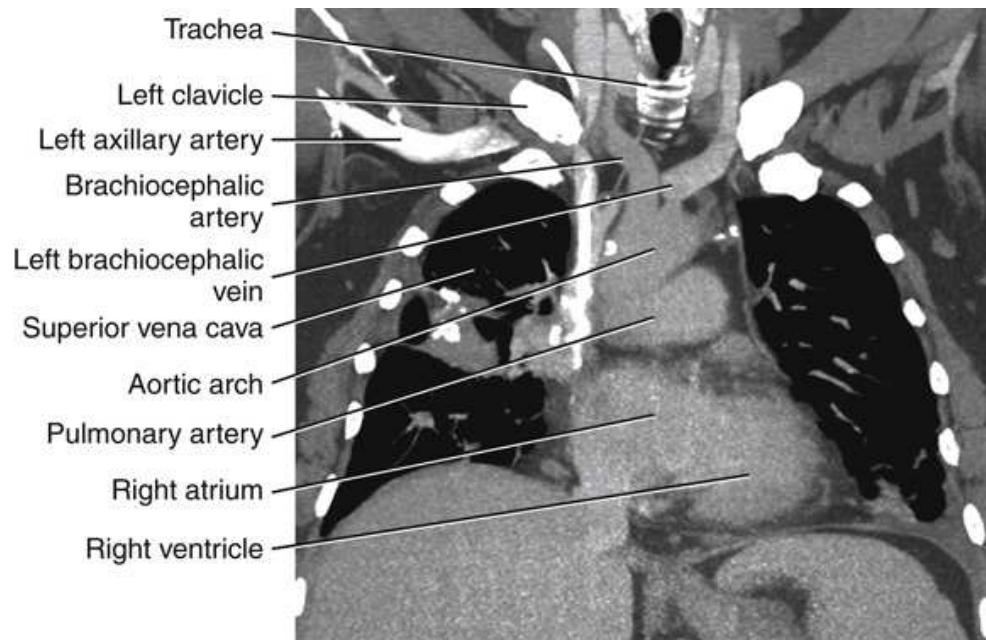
Coronal CT image of thorax corresponding to level *B* in Fig. 24.43.
